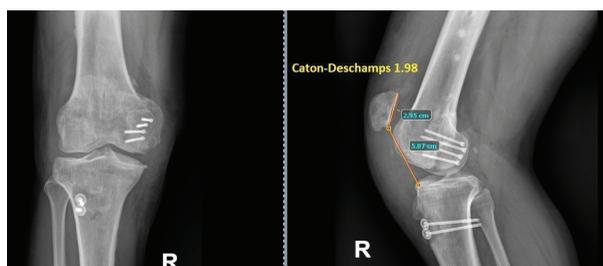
Post-operative follow-up X-ray after 10 months
